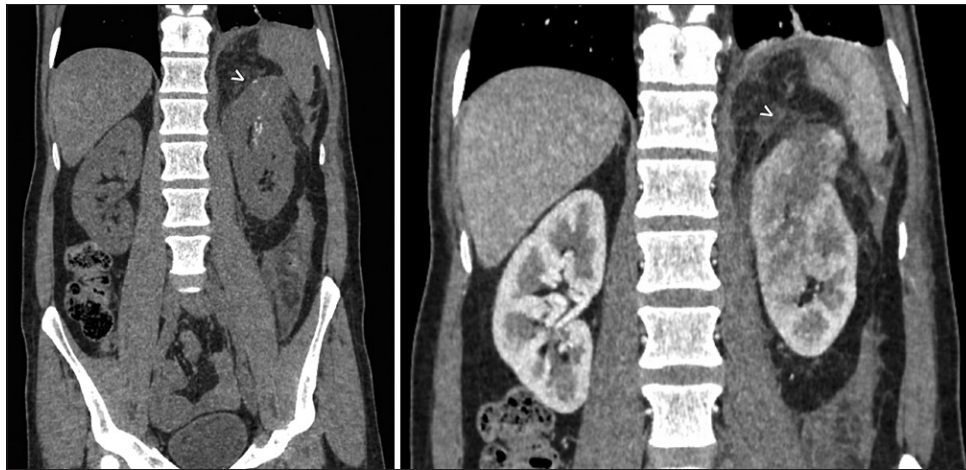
Coronal reconstructed computed tomography scan images. Left side: Showing the tumor (arrow head) with no contrast. Right side: Enhancement of the renal mass in the arterial phase (arrow head)
